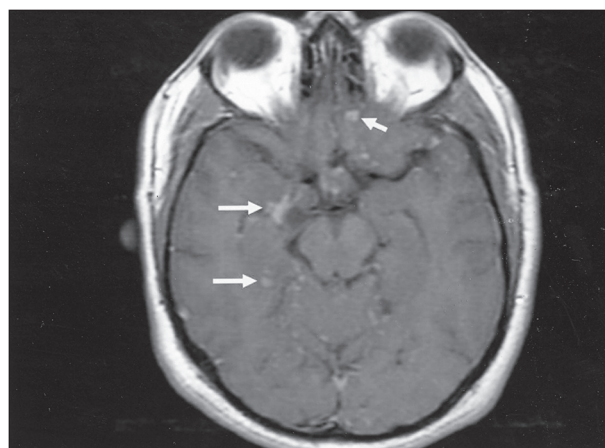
MRI brain, gadolinium-enhanced T₁ weighted axial image showing reduction in the size and number of the nodules seen in the right temporal and left frontal lobes with almost disappearance of the surrounding vasogenic edema
